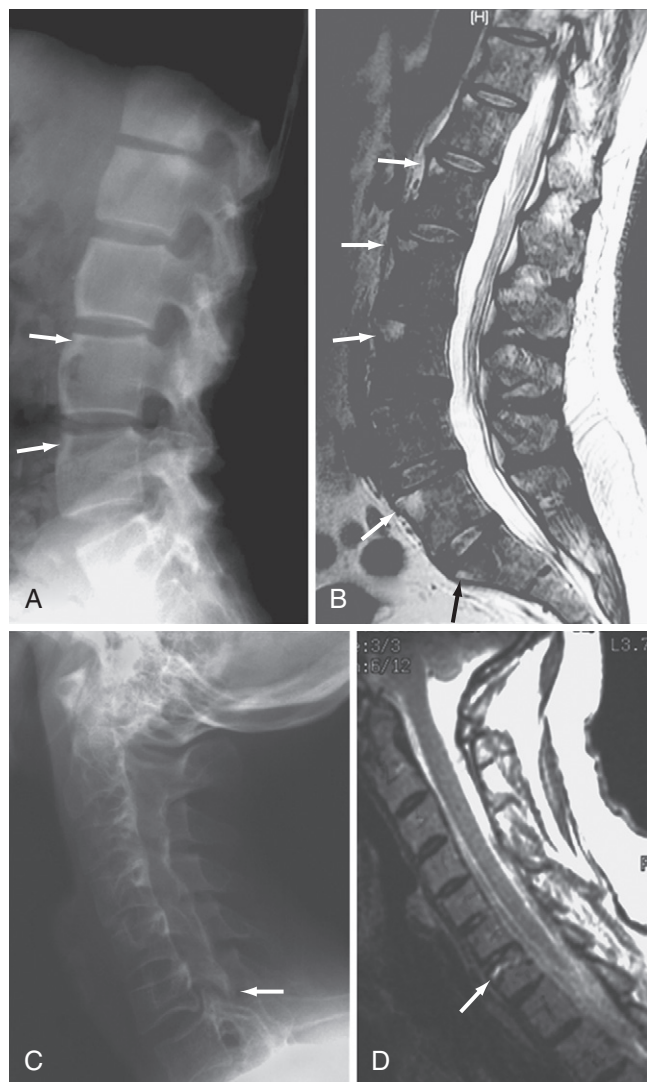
Ankylosing spondylitis (x-ray and magnetic resonance imaging [MRI]). A, Lateral x-ray of the spine shows that marked erosion at the vertebral margins has produced straight or slightly convex anterior vertebral surfaces (“squaring”). New bone formation has resulted in “shiny corners” (arrows) and contributes to vertebral body squaring. The facet joints are fused. B, Sagittal fast spin echo T2-weighted magnetic resonance (MR) image in another patient shows bone marrow edema at the anterosuperior corners of the vertebral bodies (arrows), corresponding to early osteitis. C and D, Fracture in ankylosing spondylitis. C, X-ray shows disruption of the previously fused C6-C7 facet joints (arrow) and slight anterior subluxation. D, Sagittal T2-weighted MR image confirms a high signal fracture line (arrow) through the superior aspect of C7.
